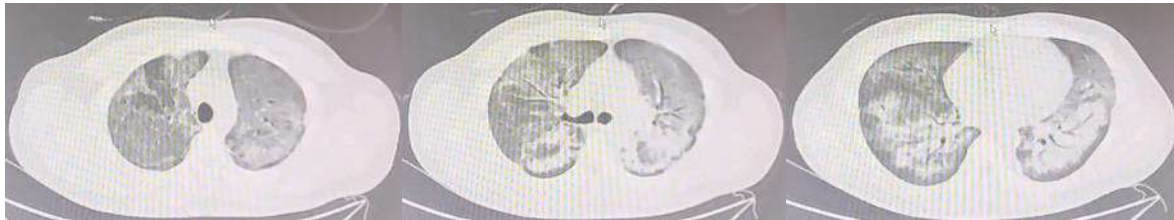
Chest CT scan of the patient's axial cut
